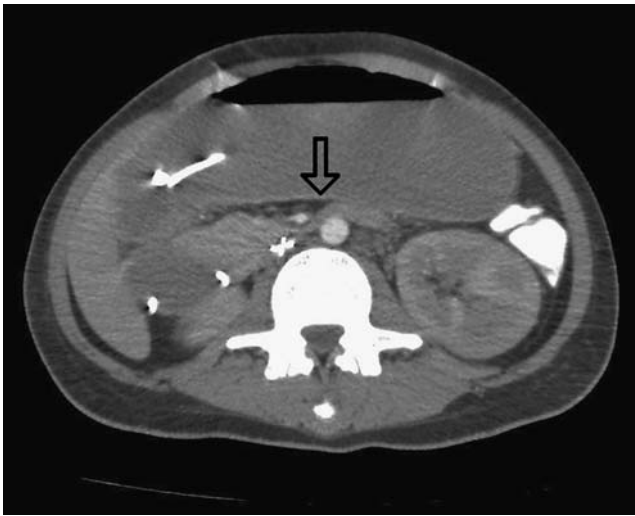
CT scan showing compression of third part of duodenum by the SMA against the aorta (*arrow*). The aortomesenteric angle in this patient was measured at 7° on a lateral reconstruction.
